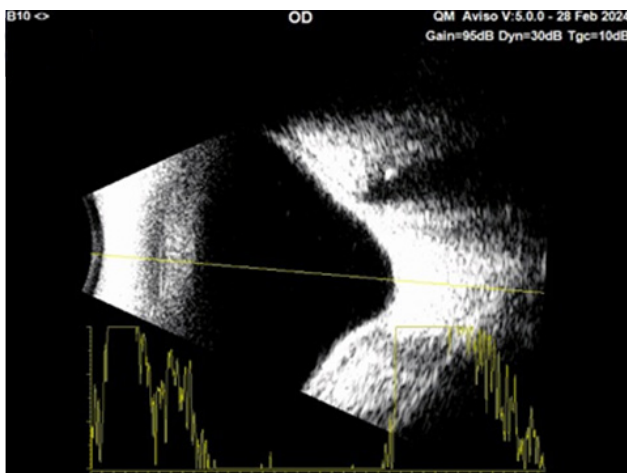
Ultrasonography (USG) of the RE showed posterior staphyloma.
